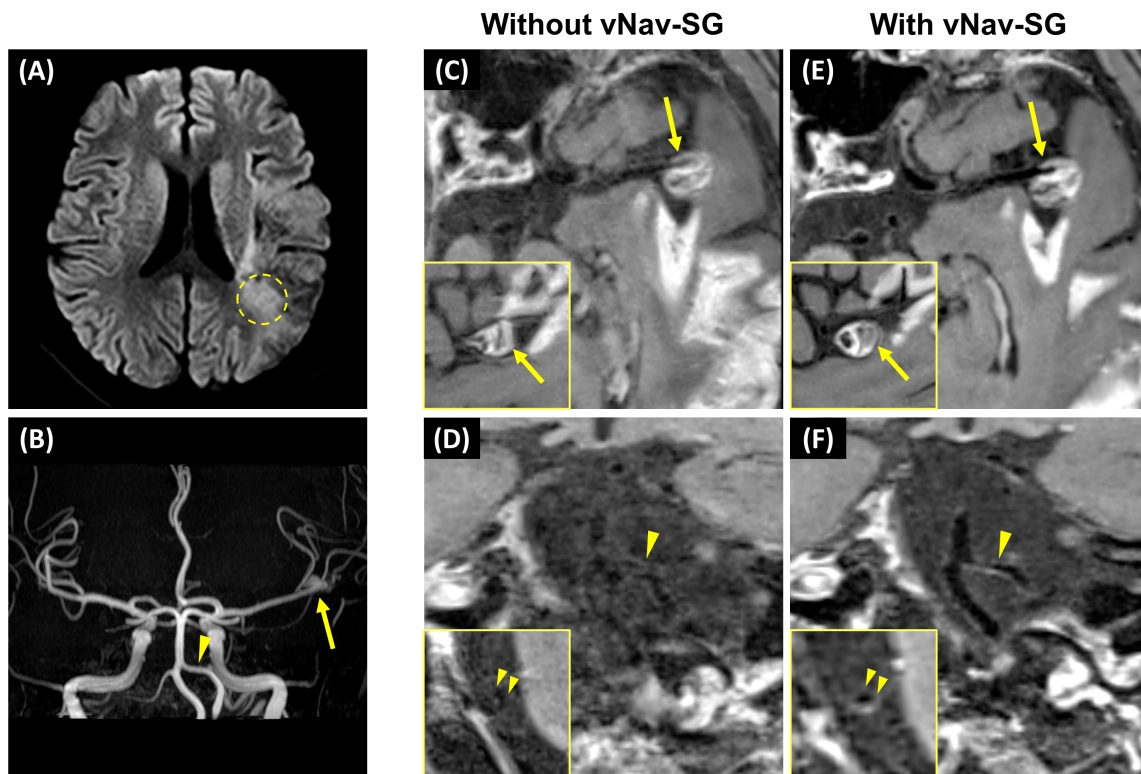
A, In a 62-year-old male patient with ischemic stroke caused by intra-aneurysmal thrombosis, an infarct marked out by the dashed circle was detected on the DWI image during clinical evaluation. B, On time-of-flight MR angiography, an aneurysm (arrow) and atherosclerotic plaque (arrowhead) were detected on left MCA M1 segment and left vertebral artery (VA) V4 segment, respectively. During the evaluation of intracranial vessel wall imaging, the patient had difficulty holding his head and neck still for the entire 8 minutes. C,D, Therefore, 3D multiplanar reconstructions of postcontrast vessel wall imaging and the cross-sectional view of the left MCA M1 segment and the left VA V4 segment showed that the images were corrupted by severe
